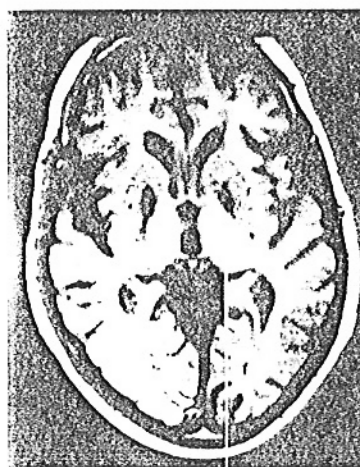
Case 2. Bilateral pallidal damage on a coronal MRI slice (T1 weighted sequence).
